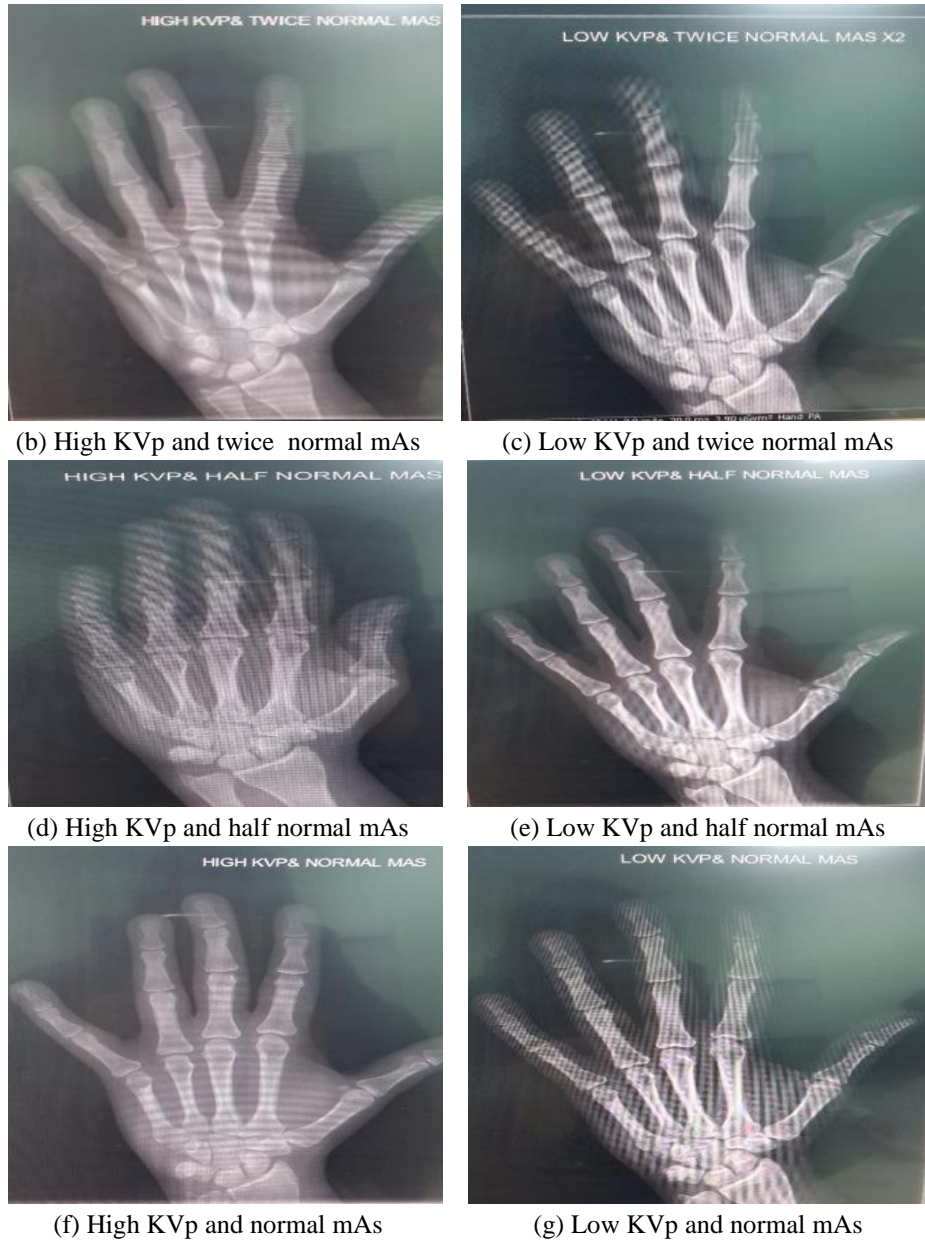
Real hand radiographs demonstrating the choice of Kvp and mAs
